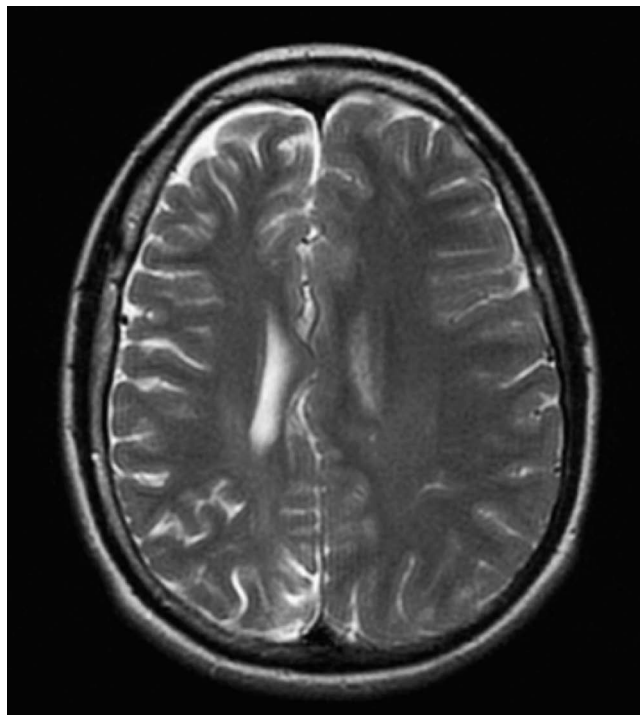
Brain MRI, in axial T2 sequence: a general atrophy of the entire right cerebral hemisphere with homolateral ventricular dilatation in the absence of vascular lesions can be observed.
